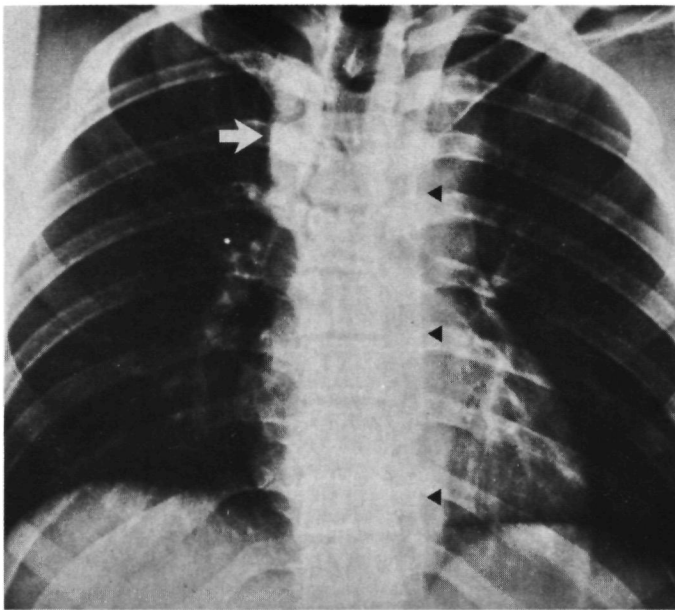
9 Male, 18 years, car-passenger, TAR. Uneventful recovery after operation. Chest X-ray: widened left paraspinal line (triangles). Widened paratracheal line (white arrow). Widening of the mediastinal shadow (9 cm) and unsharp aortic outline.
